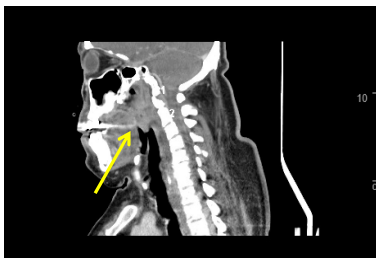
CT of cervical spine with contrast showing retropharyngeal empyema (yellow arrow) from C2 to C5.
